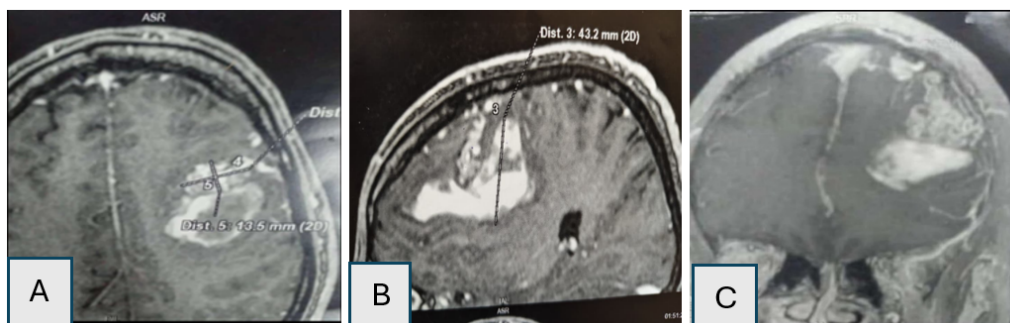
Preoperative MRI. axial (A), sagittal(B), and coronal(C) images showing the AVM nidus with intracranial hemorrhage.
